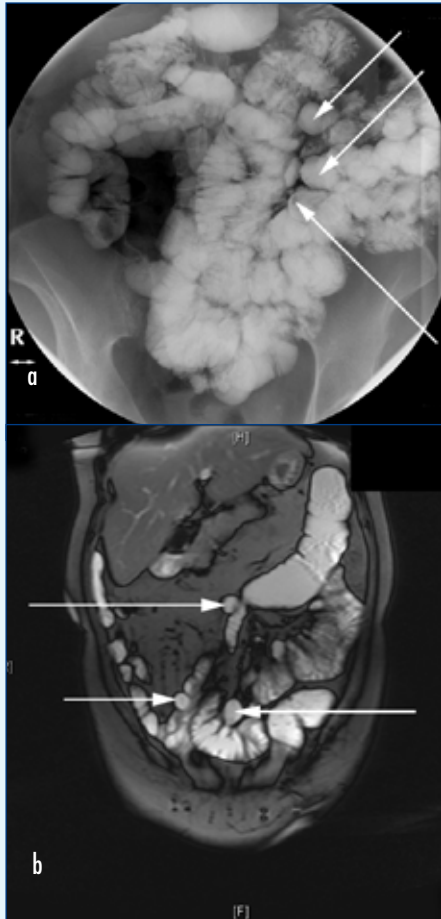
Jejunal diverticulosis. (a) Contrast study and (b) magnetic resonance imaging demonstrates multiple diverticula of varying sizes in jejunum.
